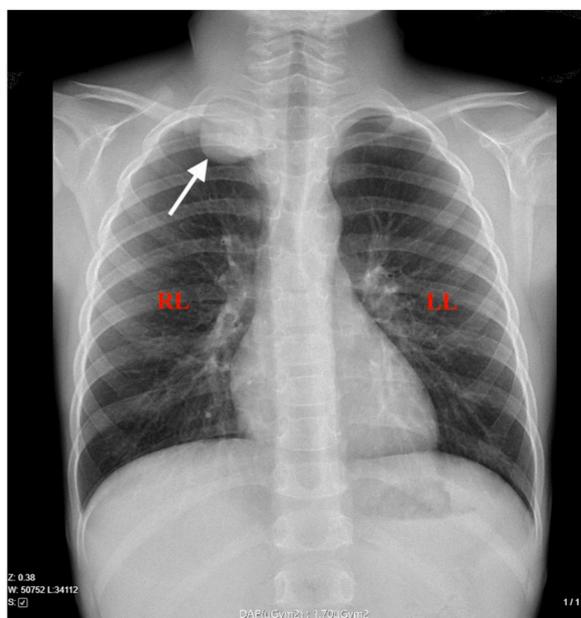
Anterior chest X-ray of the patient. A well-defined oval mass with calcifications (35×30 mm) is visible at the apex of the right lung and in the paravertebral region. RL – right lung; LL – left lung; white arrow – oval mass in the superior part of the mediastinum.
